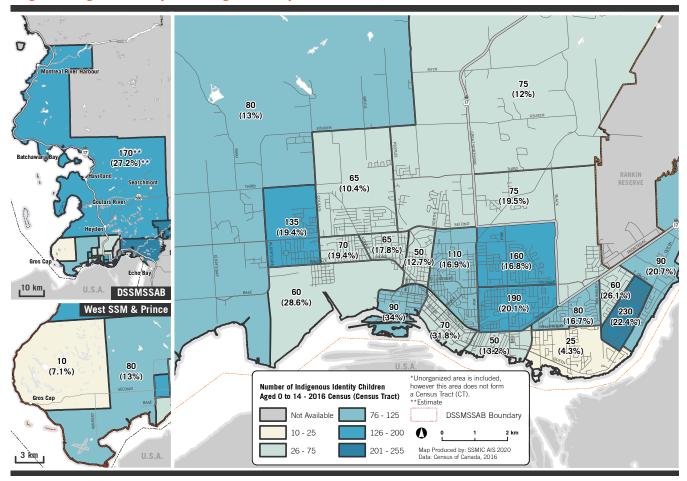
Indigenous Identity Children Aged 0 to 14 by Census Tract (CT), DSSMSSAB Area, 2016
